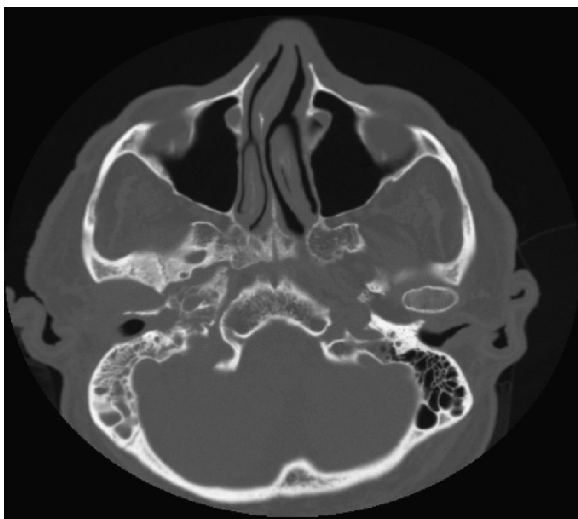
Axial computed tomographic scan shows soft tissue attenuation of the right mastoid and right middle ear, with suspected mild erosive changes of the anterior wall of the external auditory canal.
